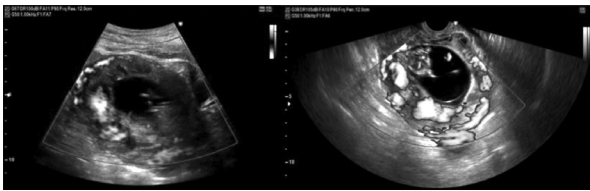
Color flow mapping (left) and power Doppler (right) of the cesarean section pregnancy showed abundant vascular flow around the mass
